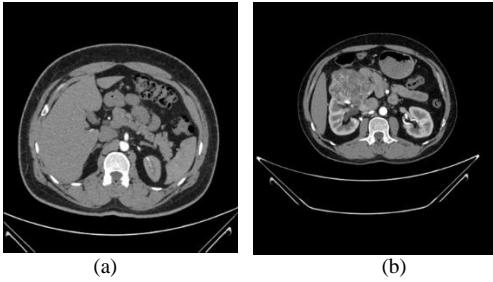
(a) CT slice of a normal kidney (b) CT slice of kidney with tumor.
